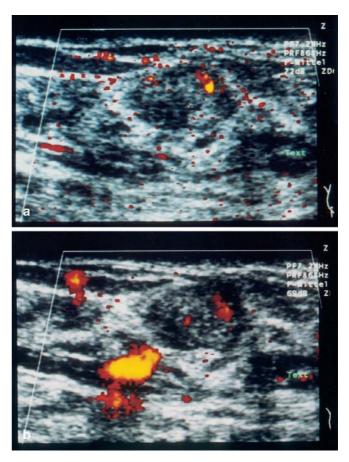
a Using plain power Doppler, only a few intratumoral vessels are visualized without signs of malignancy and without penetrating the tumor's margin. Most of the color dots within and around the tumor are artifacts. b After application of the contrast agent, the number and size of intratumoral vessels does not change significantly. As a result, this fibroadenoma has to be assessed as benign considering color Doppler criteria despite its slight hypervascularity
